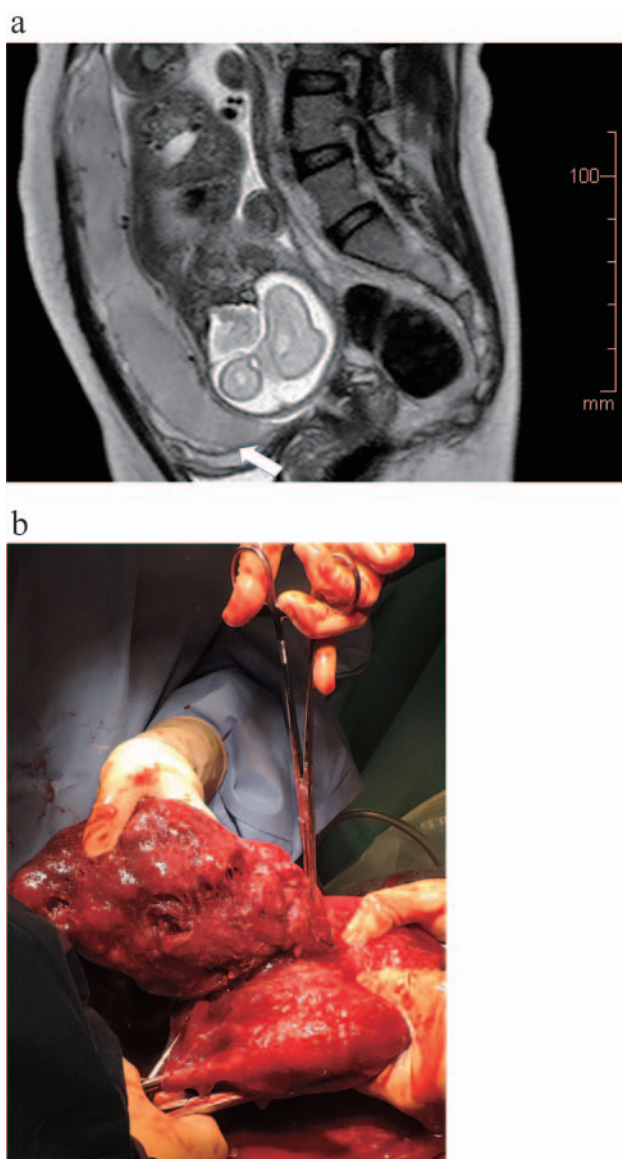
a) Magnetic resonance imaging was performed at 28 weeks of gestation. The white arrow indicates the focal loss of the zone between the anterior uterine myometrium and the placenta. From these observations, potential placenta accreta is suspected. b) A transverse incision into the uterine fundus is performed. Using this approach, the placenta and minimize bleeding can be avoided. The entire uterine cavity is visualized, thereby enabling to identify the source of the bleeding in the lower uterine segment.
